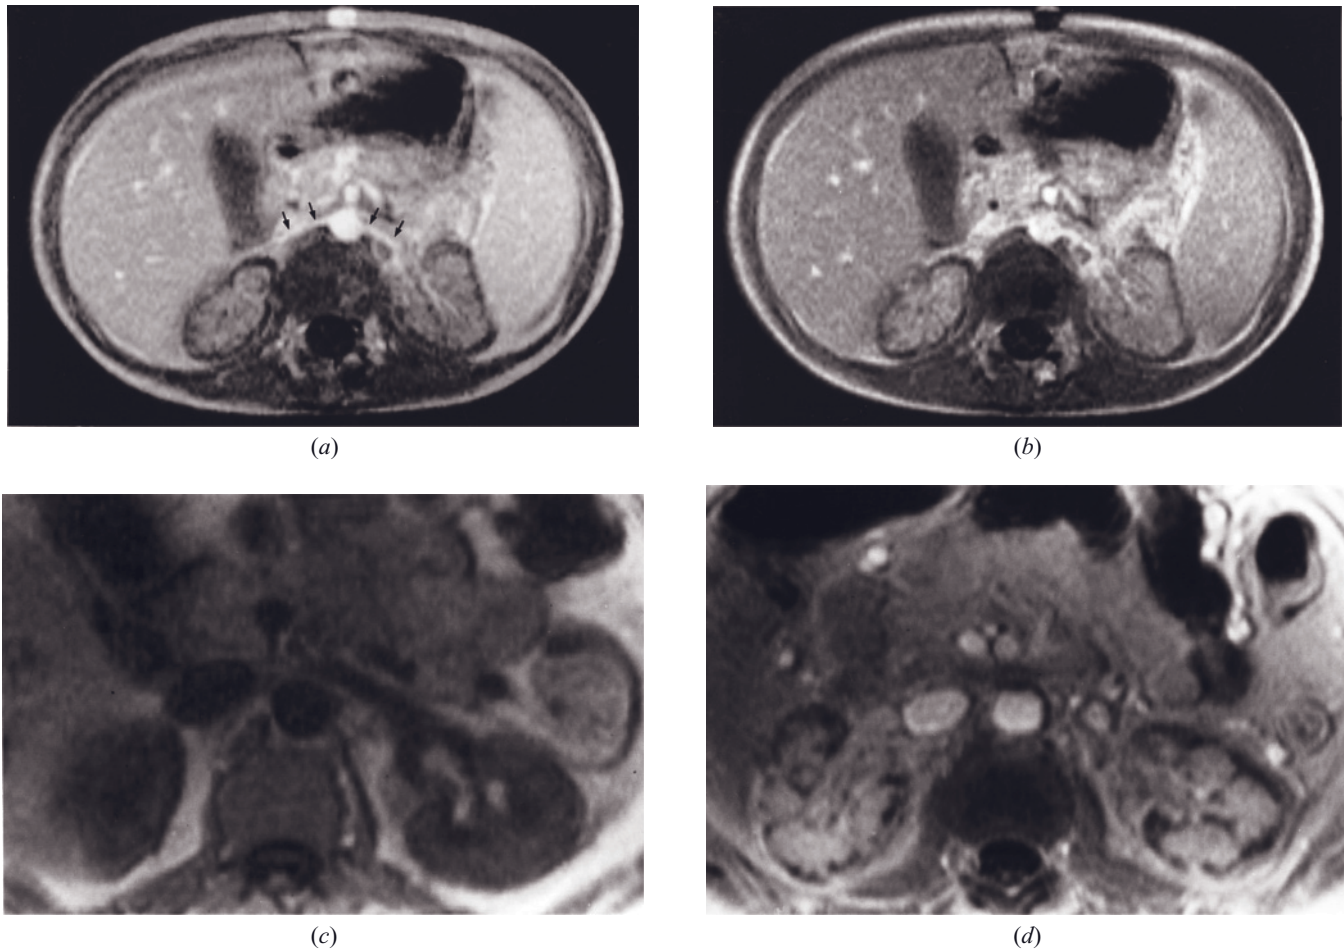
Acute cortical necrosis secondary to small-vessel disease from mixed connective tissue disease. T1-weighted immediate (a) and 45-s (b) postgadolinium SGE images demonstrate low-signal-intensity renal cortex due to lack of contrast enhancement. This appearance reflects acute cortical necrosis. Normal-appearing main renal arteries are present (arrows, a). (Reproduced with permission from Kettritz U, Semelka RC, Brown ED, Sharp TJ, Lawing WL, Colindres RE: MR findings in diffuse renal parenchymal disease. *J Magn Reson Imaging* 1: 136–144, 1996.) T1-weighted precontrast (c) and immediate postgadolinium (d) SGE images in a second patient with acute cortical necrosis. Extensive irregular linear regions that exhibit lack of enhancement are appreciated on the postcontrast image (d).
